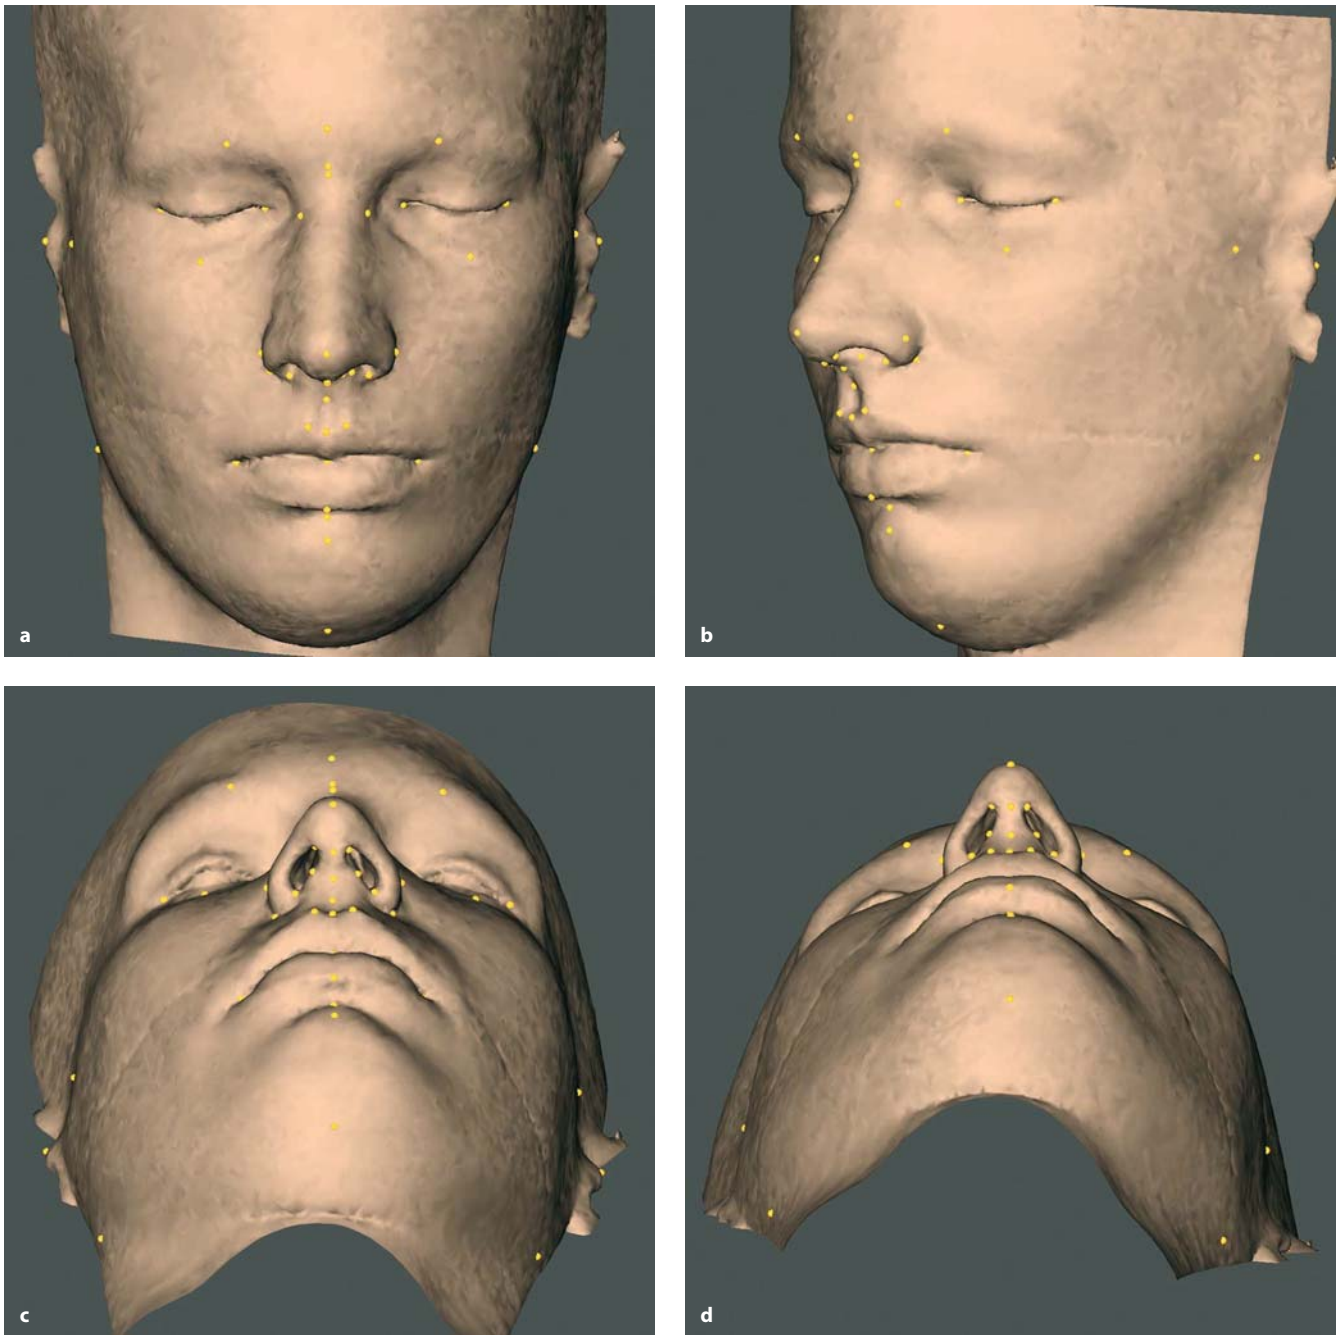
a–d. Set-up of 3-D cephalometric soft tissue landmarks. (3-D CT, patient K.C.)
